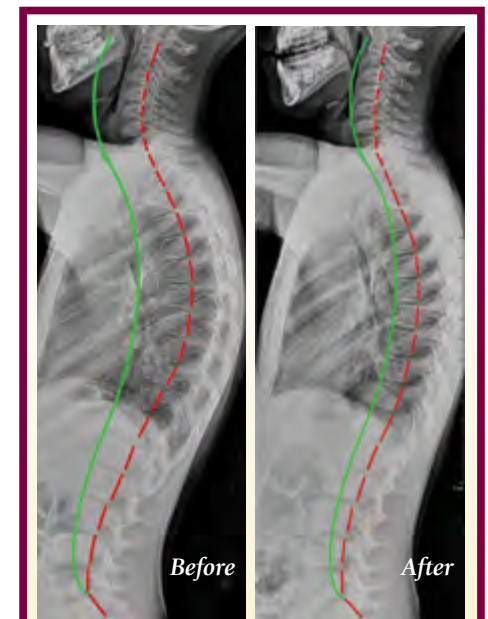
Before and After corrective care full spine lateral radiograph. On the left is the initial neutral film demonstrating a significant posterior translation of the ribcage. On the right is the follow up x-ray demonstrating considerable correction of the spine and posture abnormality.
